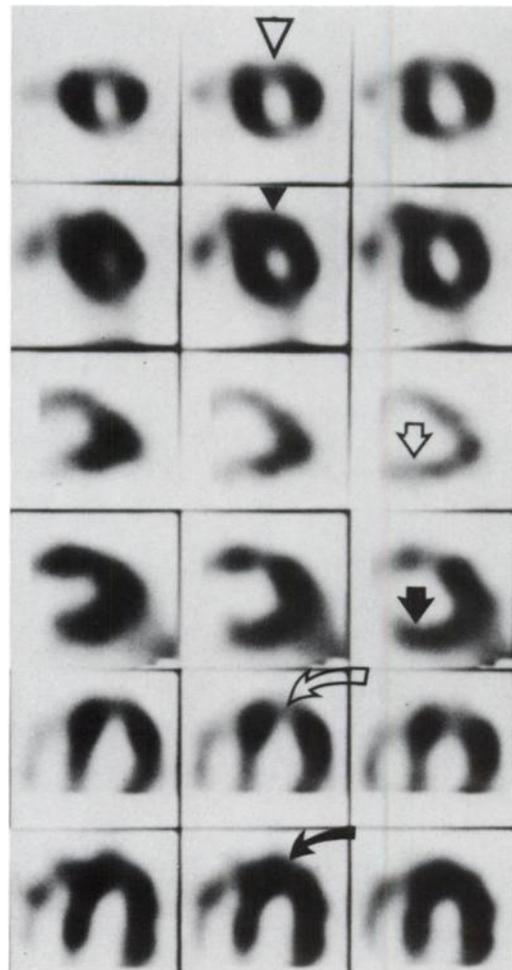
SPECT thallium images, with stress images above rest images, demonstrating short-axis (top 2 rows), vertical long-axis (middle 2 rows) and horizontal long-axis (bottom 2 rows) views. Multiple reversible perfusion abnormalities are evident. Examples of stress defects (open symbols) and their resolution on rest images (closed symbols) are pointed out in the anterior wall (triangles), inferior wall (straight arrows), and apex (curved arrows).
